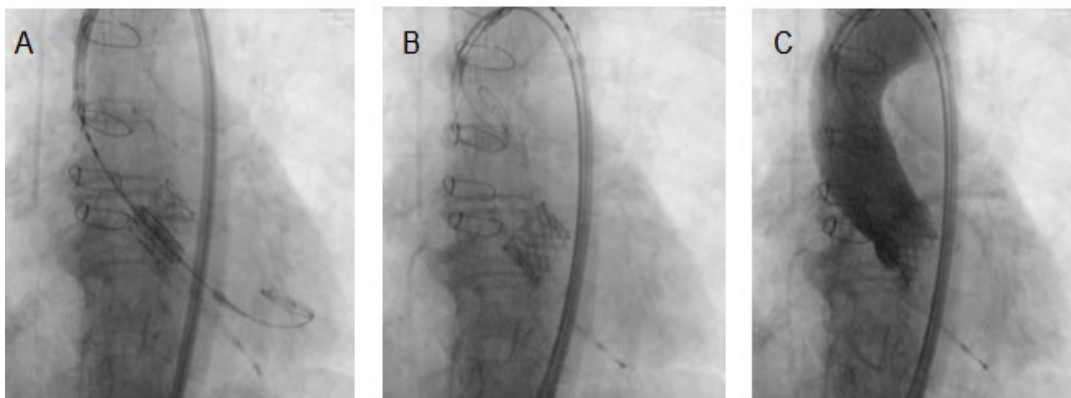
TAVI-in-TAVI with an Edwards Sapien 3 valve. (A) Using a balloon valvuloplasty, a 23 mm Edwards Sapien 3 valve was inserted into the degenerated 23 mm Edwards Sapien 3 bioprosthesis. (B) Expanded new Edwards Sapien 3 valve bioprosthesis. (C) X-ray fluoroscopy after transcatheter aortic valve deployment demonstrating a fully expanded, well-seated transcatheter prosthetic aortic valve.
